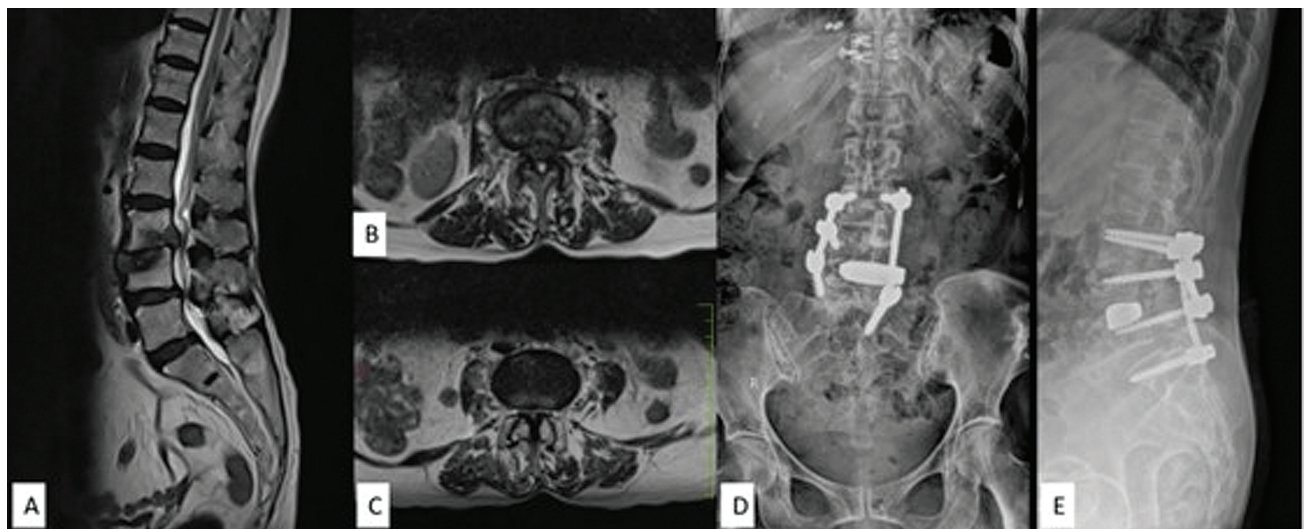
Preoperative T2-weighted image (T2WI) midsagittal (A) and axial sections at L3–4 (B) and L4–5 (C) levels showing severe canal stenosis. Patient developed bilateral lower limb weakness immediately following the surgery. Immediate postoperative anteroposterior (D) and lateral (E) X-ray showing a posterior and left lateral position of the cage.
